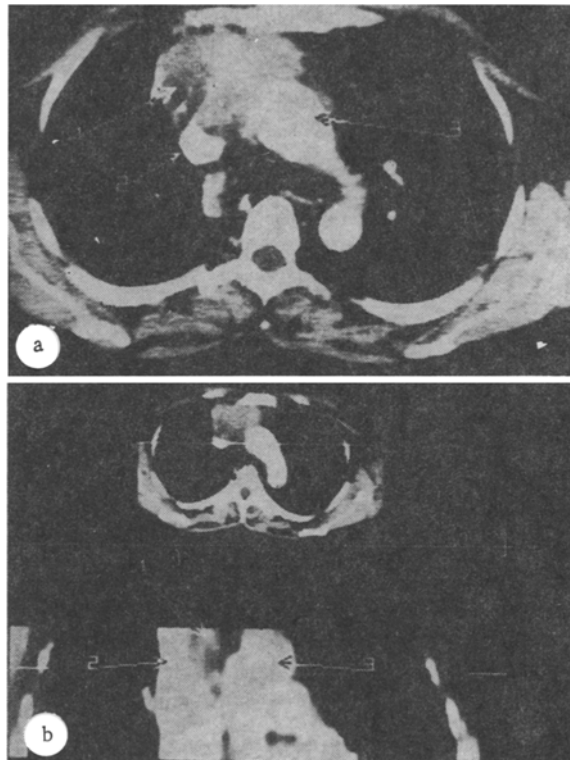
Angio-CT. Superior vena cava and arch of aorta are contrasted: 1) thymoma, 2) superior vena cava, 3) arch of aorta. a) Deformation of superior vena cava along anteromedial contour due to invasion of tumor; b) reconstruction of scan, deformation of medial contour of superior vena cava can be seen.
